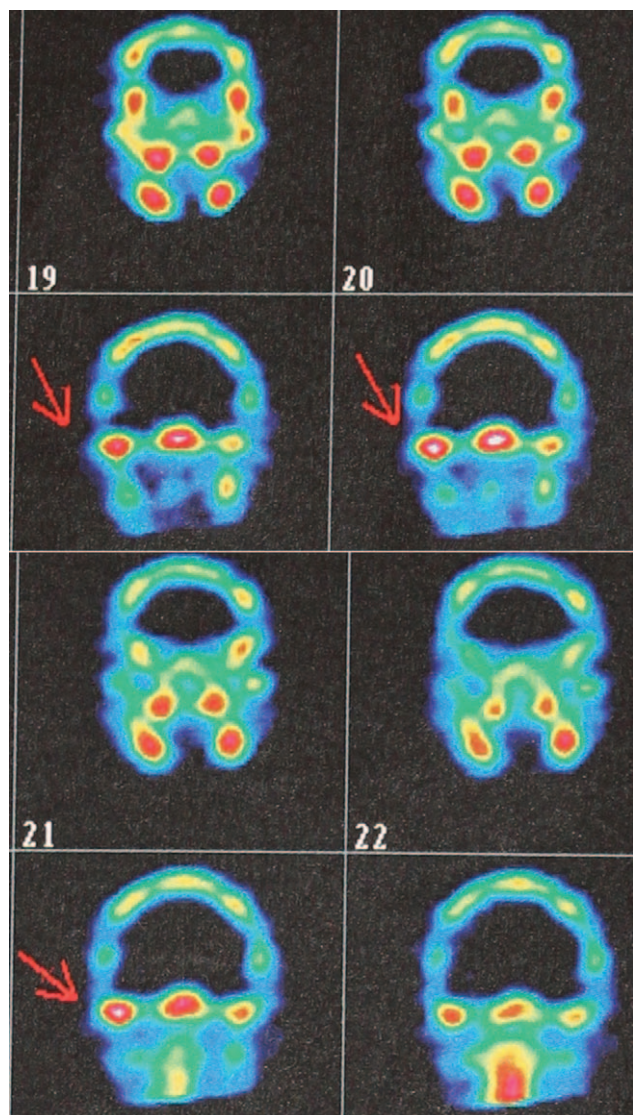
Single-photon emission computed tomography shows active growth of the left condyle in 15-year-old female with unilateral condylar hyperplasia.
